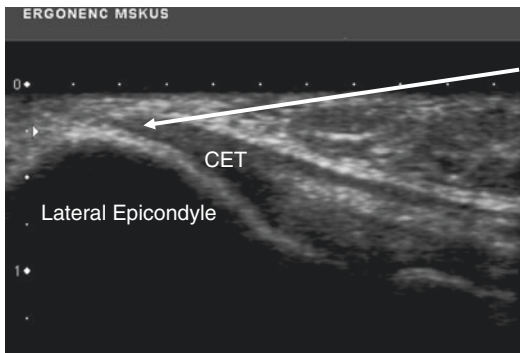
Long-axis sonogram of the common extensor tendon and radiocapitellar joint. Injection for the tennis elbow with an in-plane approach
